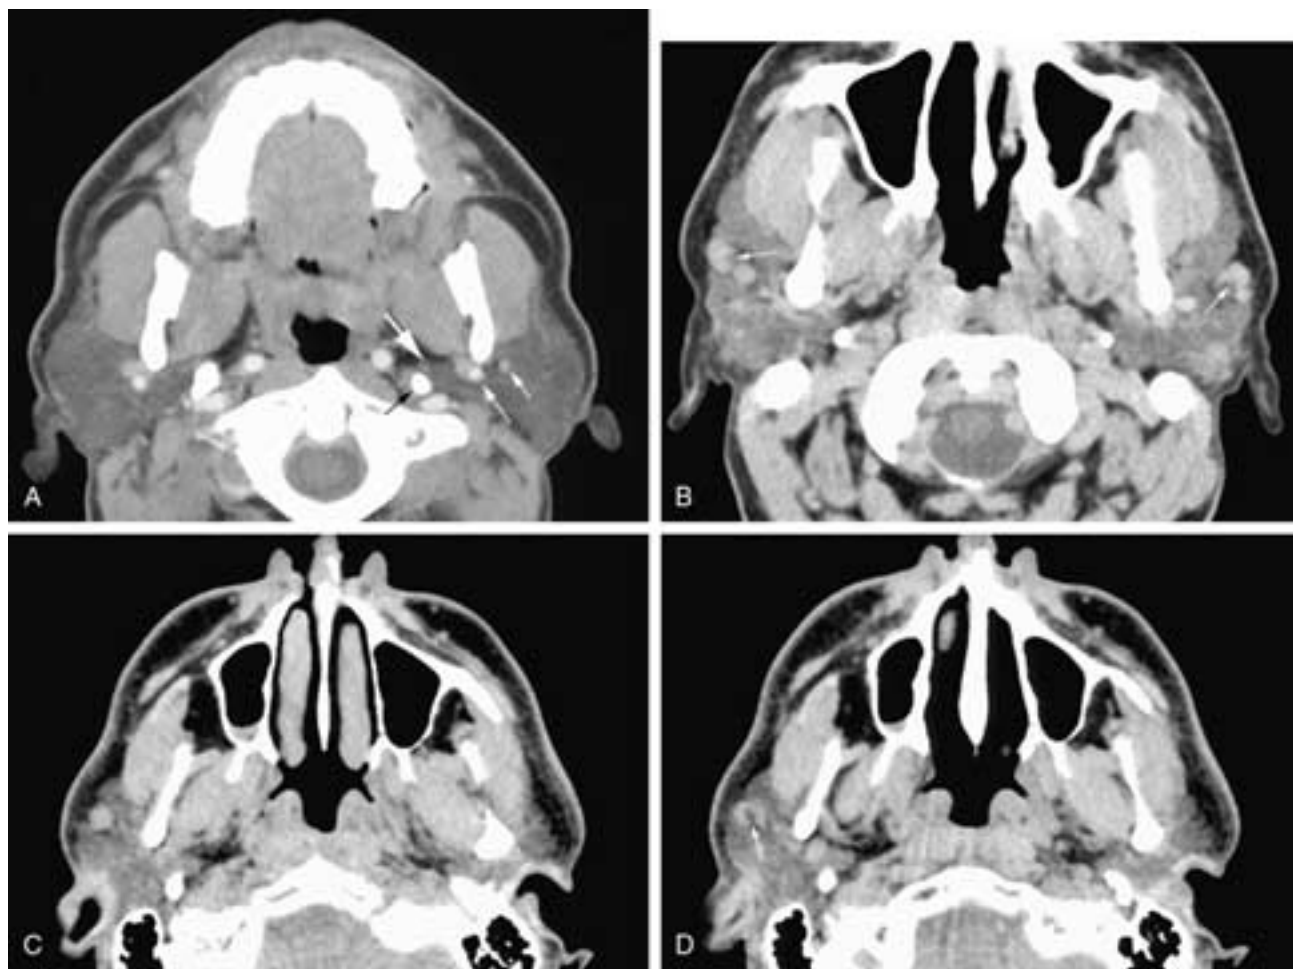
Axial contrast-enhanced CT scan (A) shows the parotid glands to be of lower attenuation than muscle but of higher attenuation than subcutaneous fat. The retromandibular vein (*long thin arrow*) and the external carotid artery (*short thin arrow*) are seen. At this level, the artery is lateral as it starts to ascend to become the superficial temporal artery. The styloid process (*black arrow*) is dorsal to the deep portion of the parotid gland (*large white arrow*) as it projects into the parapharyngeal space. Axial CT scans (B to D) show examples of parotid lymph nodes. Note the superficial location of the nodes and fat in the hilum (*arrow* in B).
